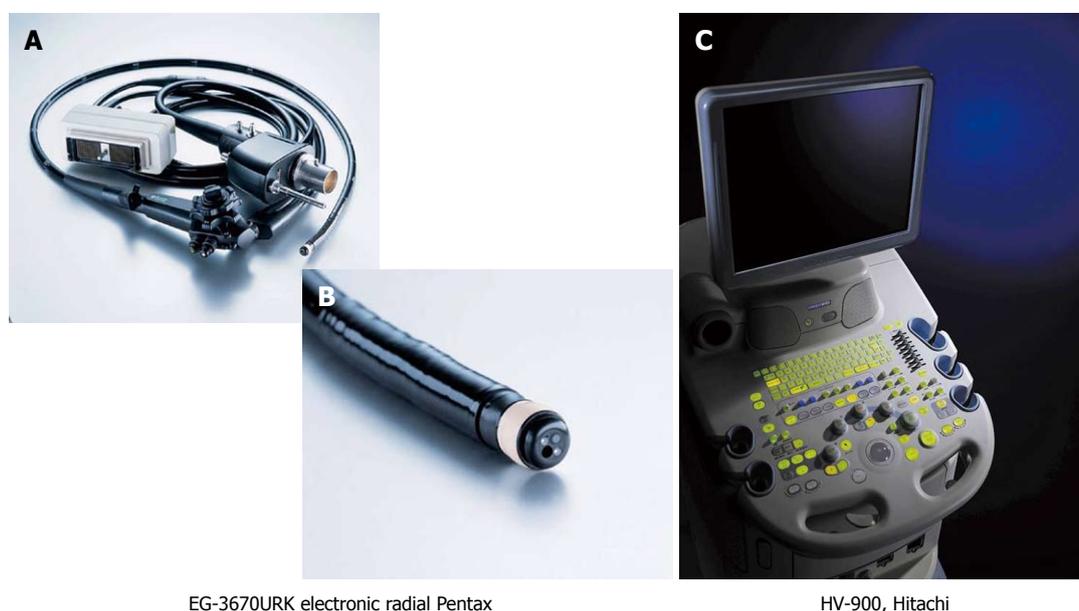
Endoscope and ultrasound machine (Setting-1). A, B: The images indicate the whole view of the Pentax endosonoscope (EG-3670URK) and the tip of the scope; C: The image shows the ultrasound machine (HV-900, Hitachi, Japan).
